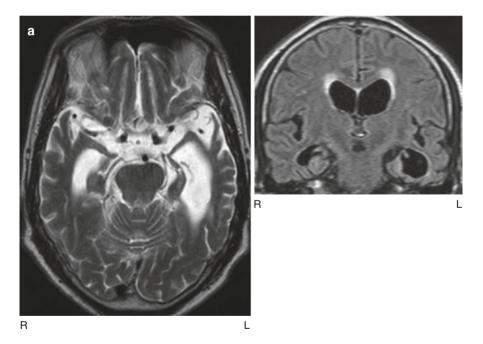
(a) MRI (T2: *left*, axial) and (FLAIR: *right*, coronal) images of SD. There is bilateral anterior temporal atrophy disproportionately affecting the left temporal lobe. (b) The result of VSRAD analysis (normal healthy volunteers vs. SD individual). The colored areas show the regions with atrophy in the SD individual compared with the normal healthy volunteers. (c) 99m Tc-ECD SPECT images of SD individual. The axial views demonstrate bilateral temporal hypoperfusion disproportionately affecting the left temporal lobe. (d) The result of eZIS analysis (normal healthy volunteers vs. SD individual). The colored areas show the regions with hypoperfusion in the SD individual). The colored areas show the regions with hypoperfusion in the SD individual).
